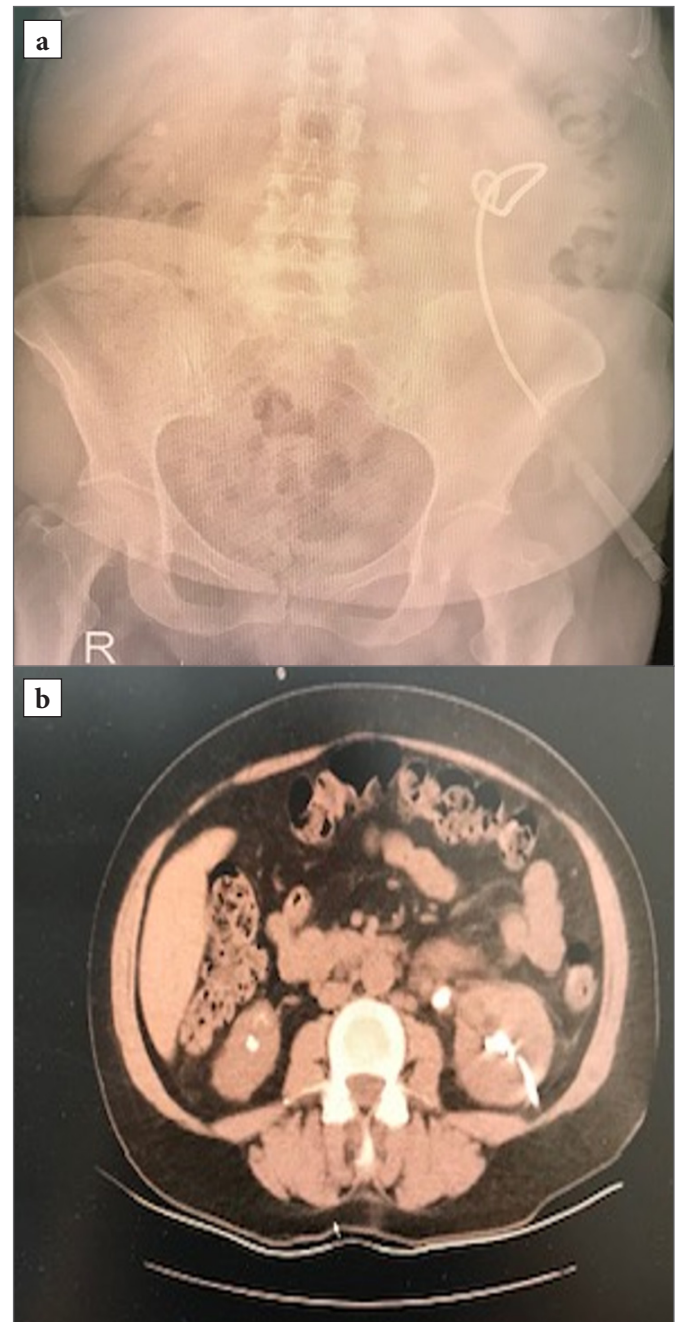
A nephrostomy tube was placed in the left kidney for decompression. a) Nephrostomy Tube on KUB, b) Nephrostomy Tube on CT scan
